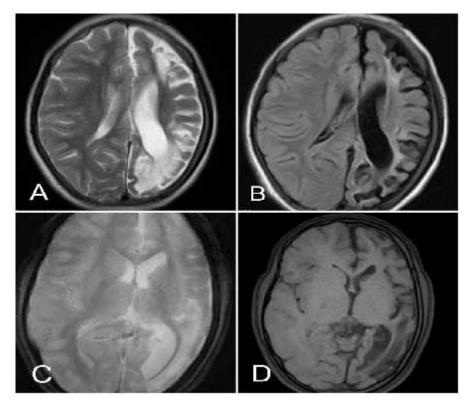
A.T2WI showing striking left cerebral hemiatrophy with enlarged left lateral ventricle, midline falx and interhemispheric fissure. B. FLAIR sequence showing gliosis of left cerebral hemisphere. Thickening of calvaria noted on left side. C. GRE sequence showing no calcification.
